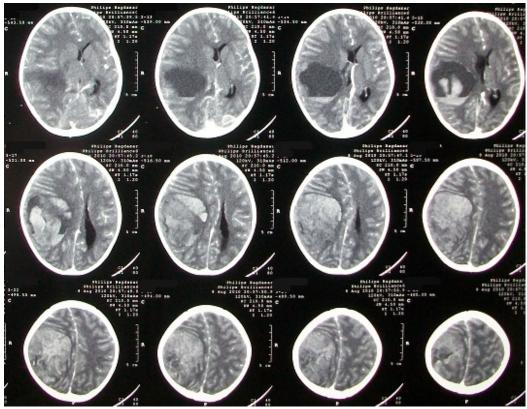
Preoperative CT-scan with contrast enhancement
